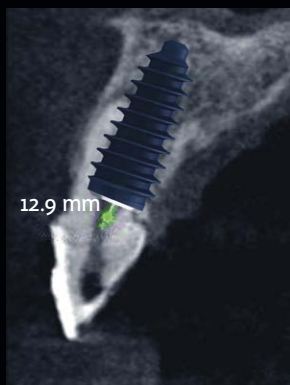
The patient's CBCT image with the correctly determined implant position.
